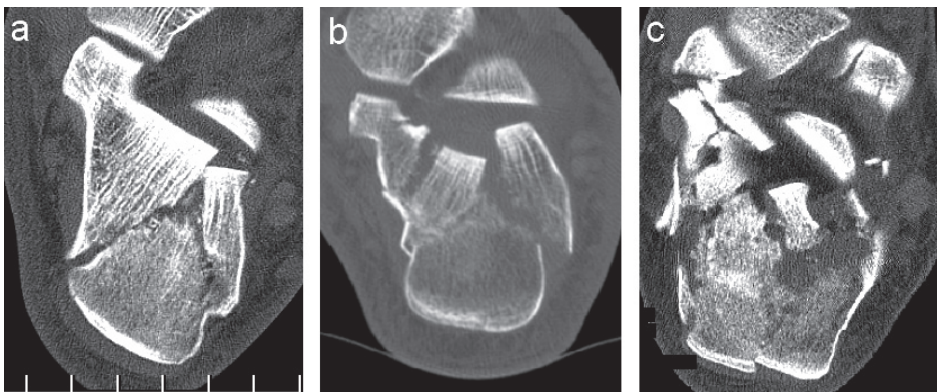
CT-classification according to Sanders: a. type IIA, b. type IIIAC, en c. type IV fracture
